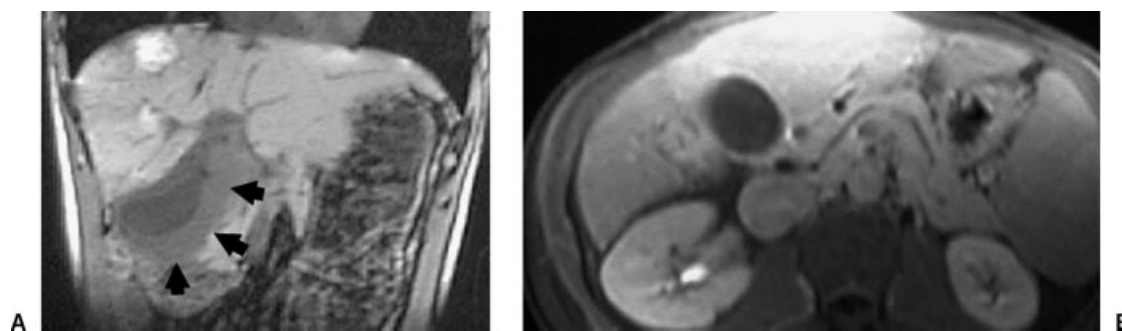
(A) Coronal T1-weighted magnetic resonance imaging (MRI) of a 50-year-old man with metastatic small bowel sarcoma and right upper quadrant pain 4 weeks following TACE, showing extensive gallbladder wall thickening (arrows) consistent with chemical cholecystitis. The patient was managed conservatively. (B) Transverse T1-weighted MRI obtained 3 months later showing return of the gallbladder to a normal appearance. Cholecystectomy was unnecessary.
